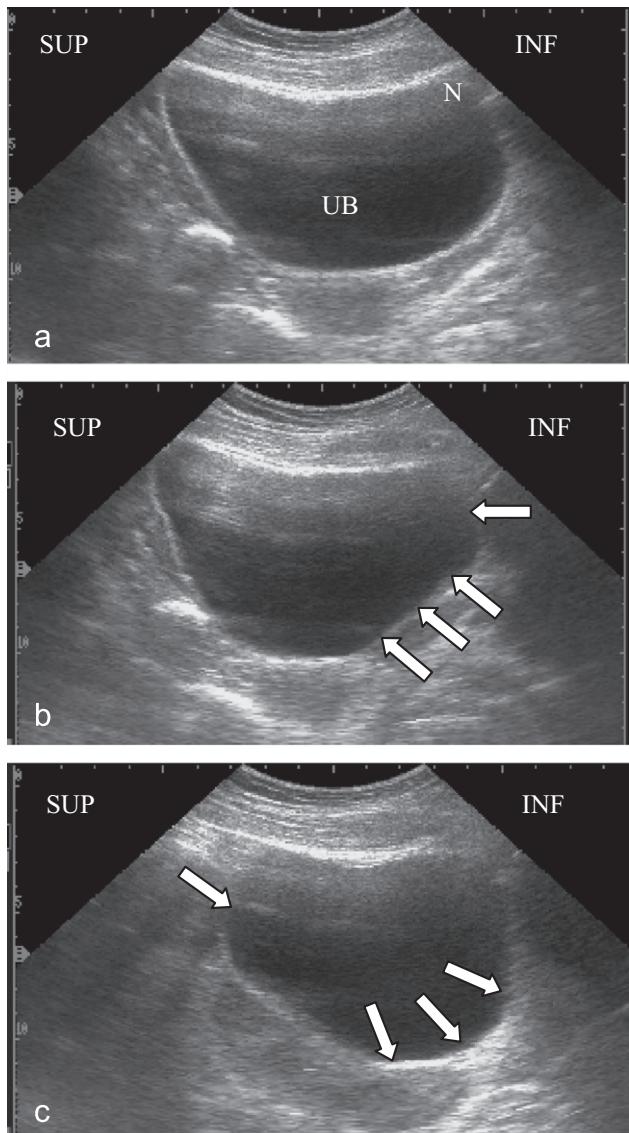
Ultrasound image of the bladder (parasagittal view). (a) Bladder at rest. UB, urinary bladder; N, neck of the bladder; SUP, superior; INF, inferior. (b) Correct recruitment of the PFM results in an indentation of the posteroinferior aspect of the bladder (arrows) and a cranioventral shift (arrow). (c) A Valsalva maneuver results in a deformation of the bladder shape (arrows) and a caudodorsal shift (arrow). (Reproduced with permission from Diane G. Lee Physiotherapist Corp.)
